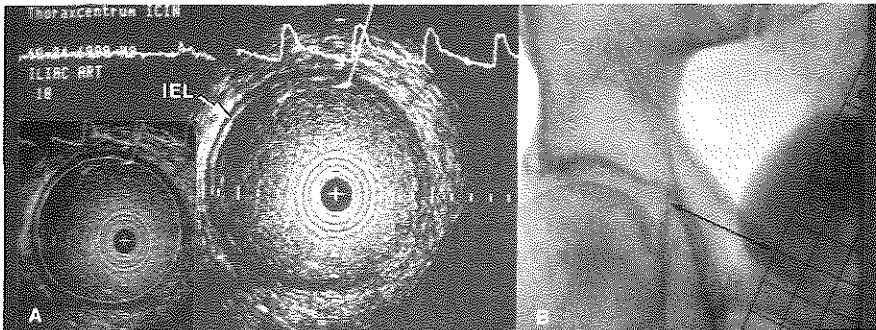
(A) Ultrasonic cross section of the iliac artery without and with contour tracing of the arterial lumen. (B) Corresponding angiogram of the same patient showing the grid. Ultrasonic and angiographic measurements were taken at level 10. The intima-internal elastic lamina echo (IEL) has been used as a landmark to trace the lumen contour.
